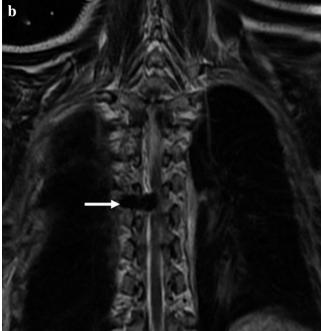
MRI showing axial T1 weighted (a) and coronal T2 weighted (b) images showing a lobulated hypo-intense mass (arrows) extending across in the intervertebral foramen into the spinal canal causing compression of the spinal cord.
